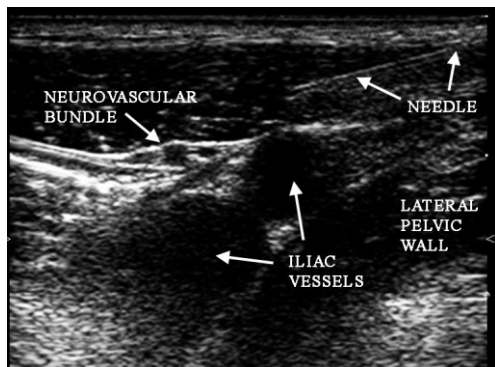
Sonogram of ilioinguinal block in a child
